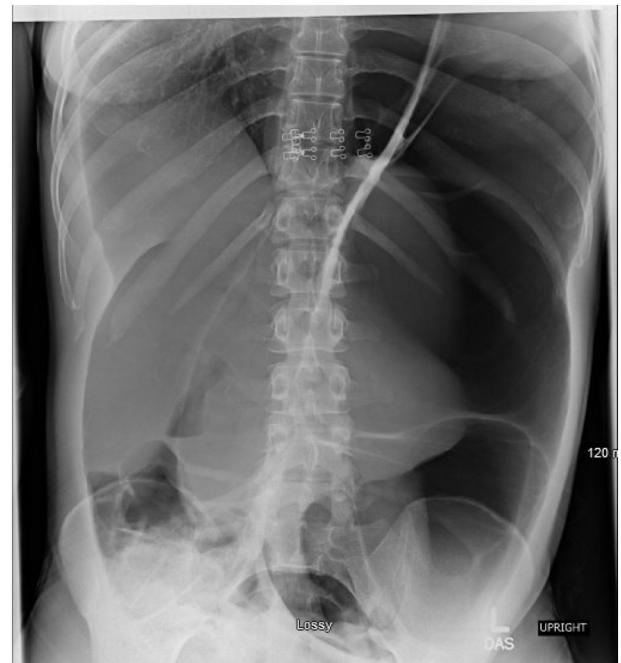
Abdominal x-ray demonstrating severe gaseous colonic dilation resulting in significant left hemidiaphragm elevation.
